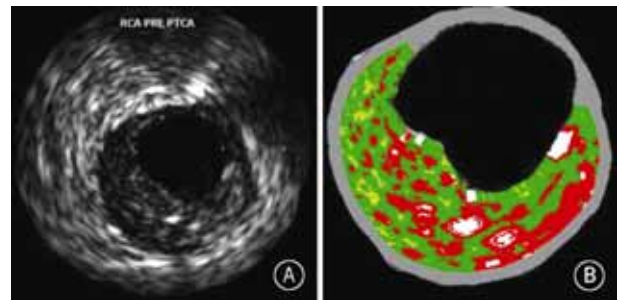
Intravascular ultrasound (IVUS) grey scale image (A) and VH-IVUS image (B) of the thin cap fibroatheroma (TCFA). Colour coded tissue shows as green (fibrotic), yellow-green (fatty fibrous), white (dense calcium), and red (necrotic core).
